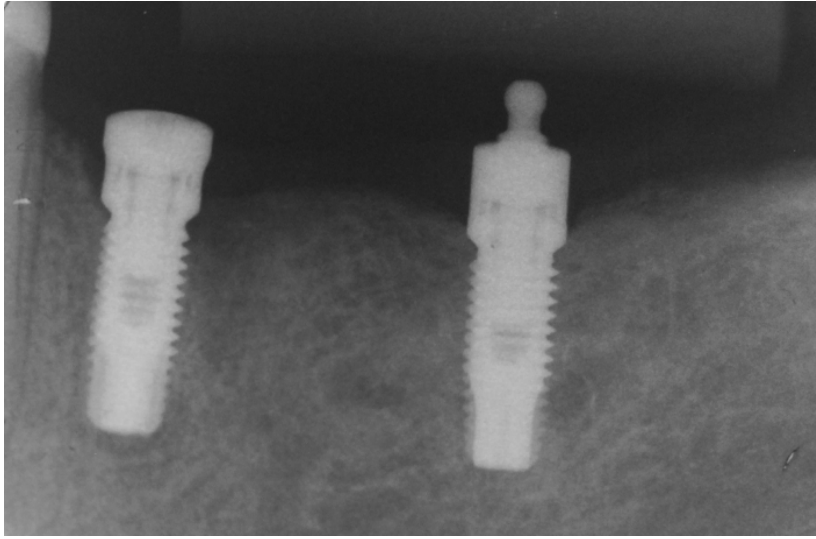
Follow up periapical radiograph of osseointegrated implants and ball abutments.
